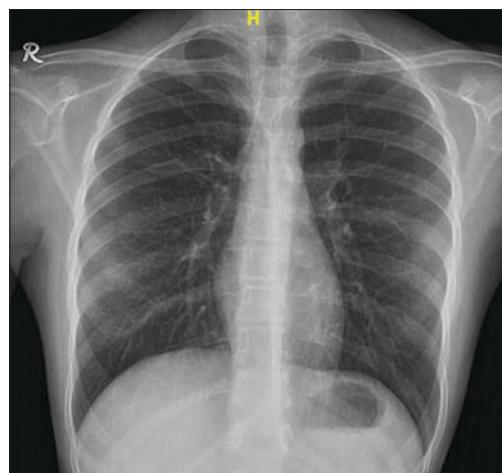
Chest X-ray showing microcardia (computed tomography ratio: 38.3%)
